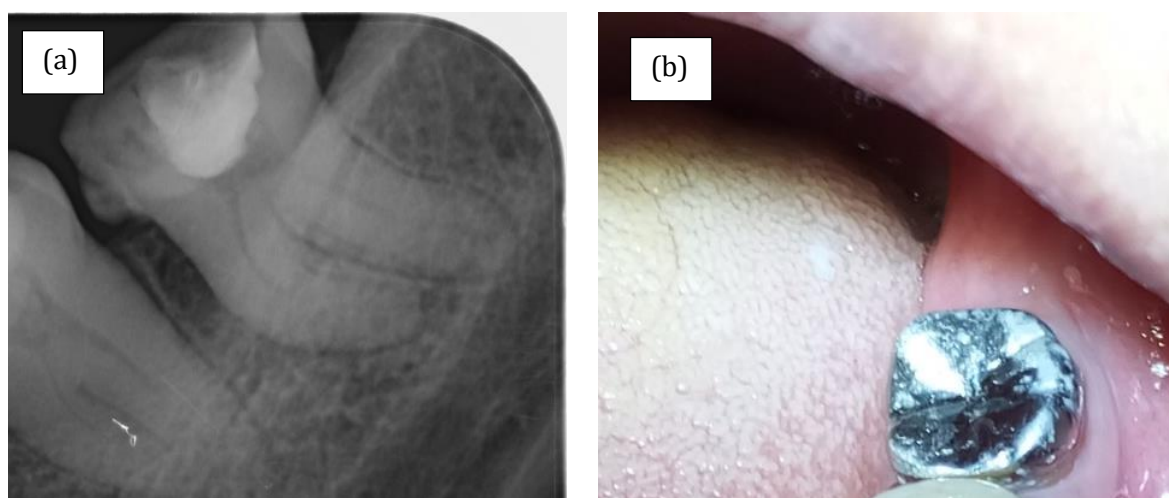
(a) Periapical of 37. (b) Full metal onlay on 37.
